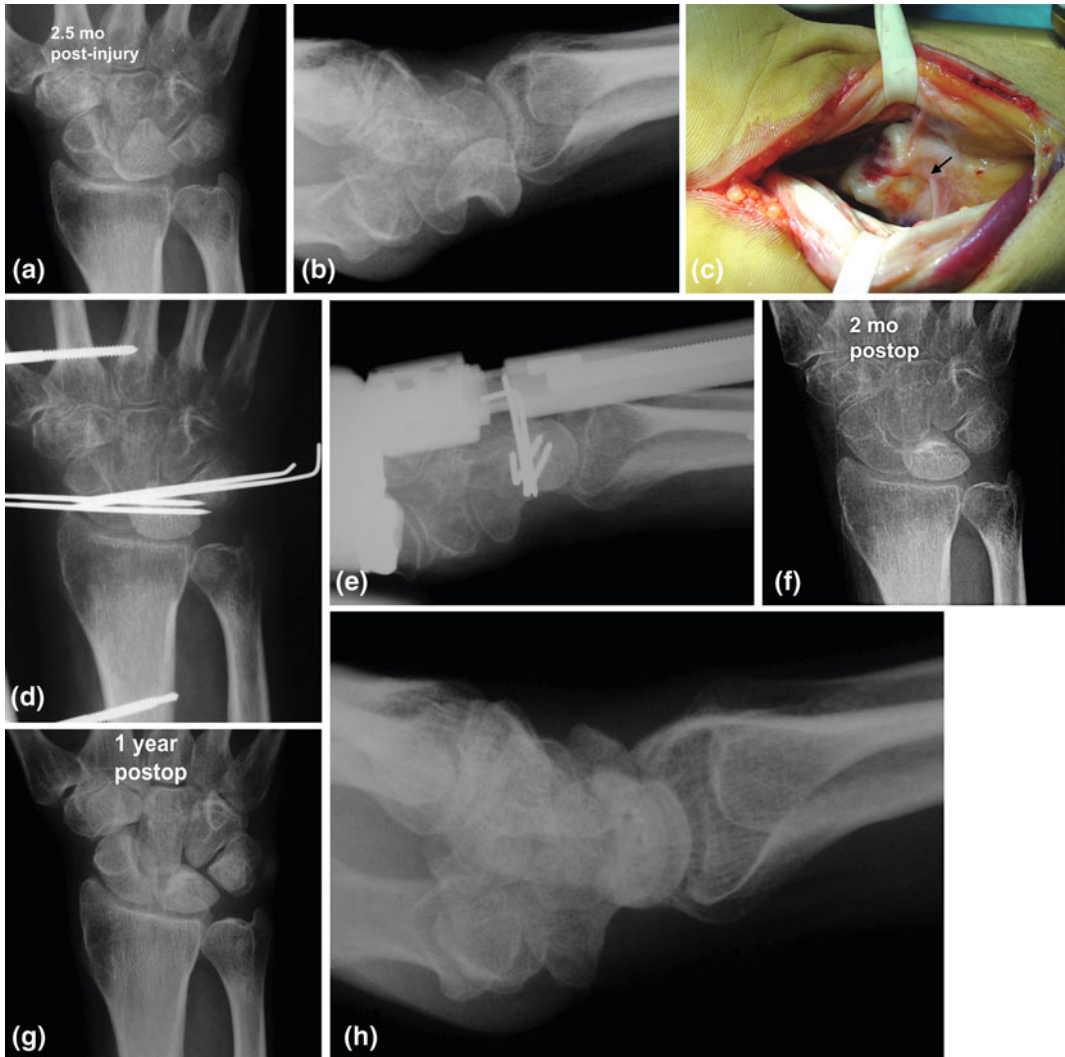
Male, 58-years old, a 2.5 months old lunate dislocation (a, b); arrow shows the only vascular supply to the volarly dislocated lunate (c); postop X-rays (d, e);
